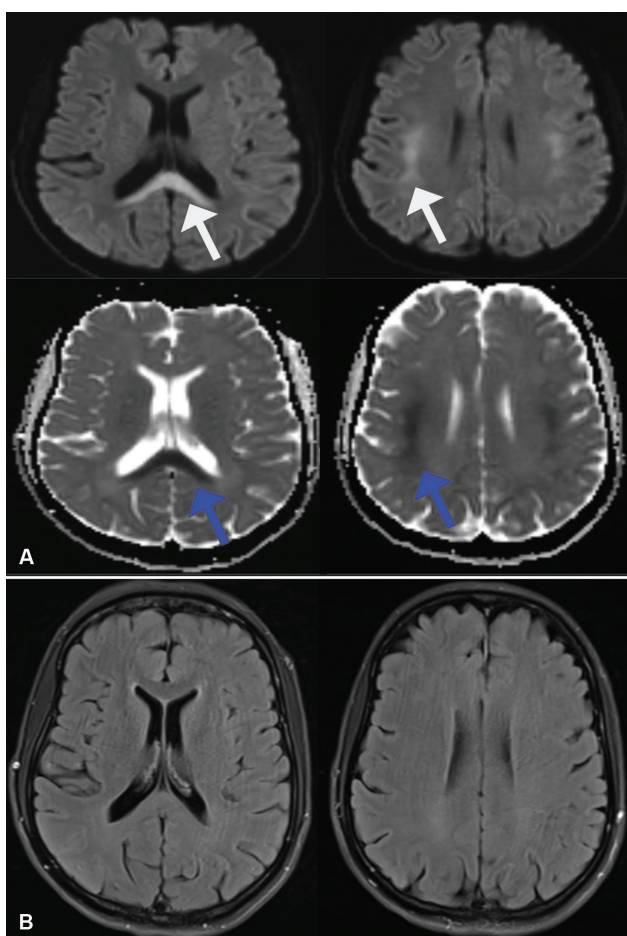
(A) Diffusion-weighted (DW) sequence showing inverted hyperintensities in the corpus callosum and bilateral subcortical regions (white arrow) with corresponding hypointensities on apparent diffusion coefficient (ADC) sequences (blue arrows). (B) T2-weighted (T2W) sequences not showing any corresponding abnormality.
